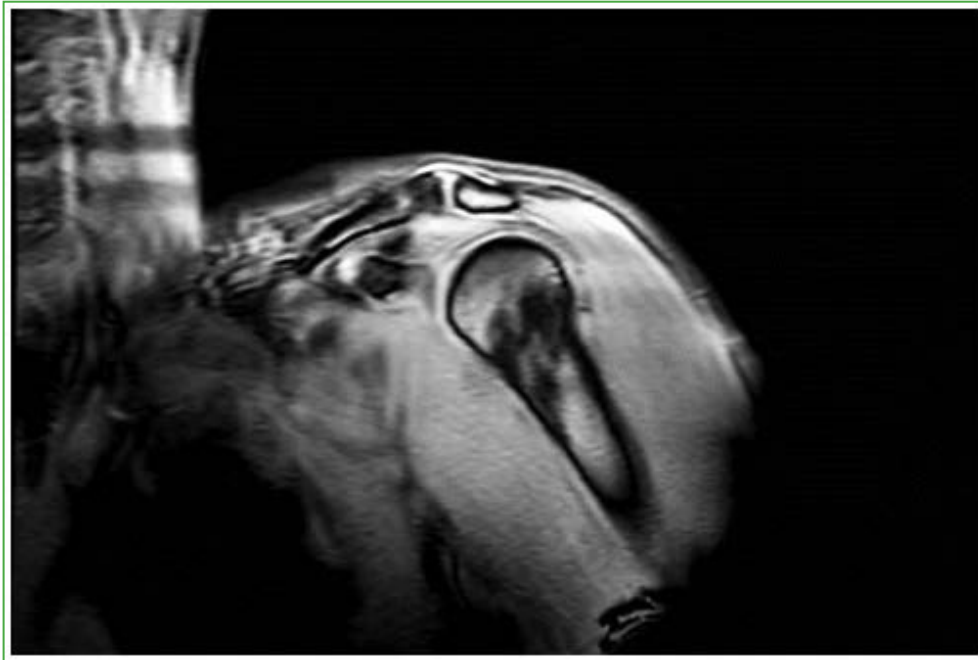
Coronal MRI of the shoulder showing an extensive area of fiber disruption with heterogeneous signal intensity in the superolateral portion of the pectoralis major.
